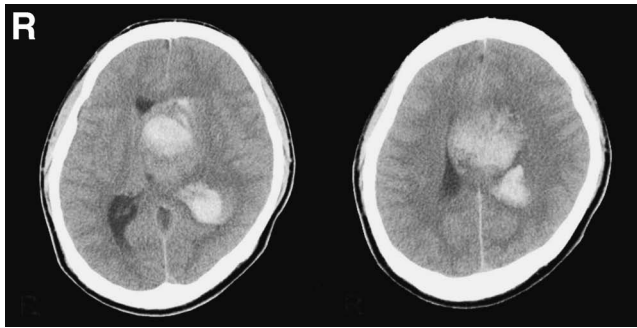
Computed tomography scans on admission indicating an enlarged mass lesion, 56 mm in maximum diameter, in the left lateral ventricle associated with massive intratumoral and intraventricular hemorrhage.
